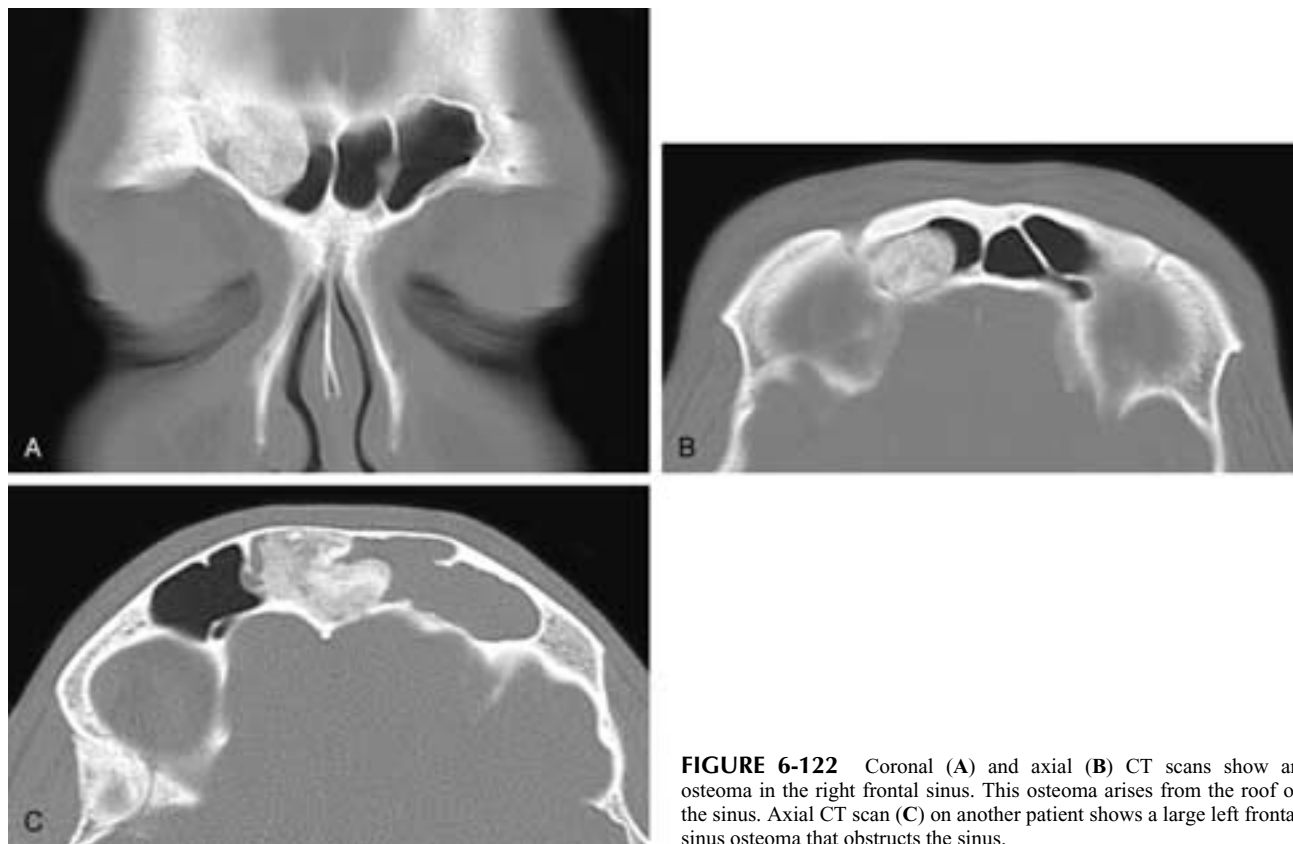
Coronal (A) and axial (B) CT scans show an osteoma in the right frontal sinus. This osteoma arises from the roof of the sinus. Axial CT scan (C) on another patient shows a large left frontal sinus osteoma that obstructs the sinus.
